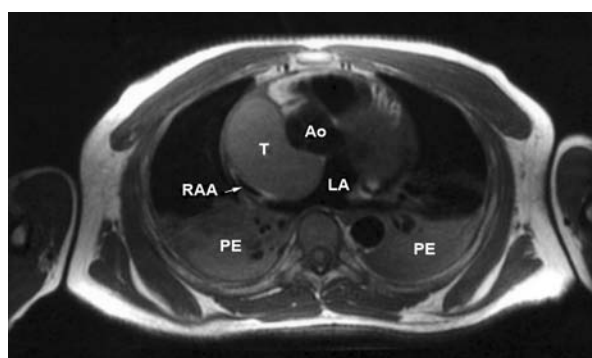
Axial image through the heart, using double inversion recovery (T₁-weighted) magnetic resonance imaging, shows a large soft-tissue mass, appearing to be in the right atrium and exerting mass effect on the left atrium without evidence of invasion. Bilateral pleural effusions are also visible. The mass is homogeneously isointense on T₁-weighted imaging and hyperintense on T₂-weighted imaging.
